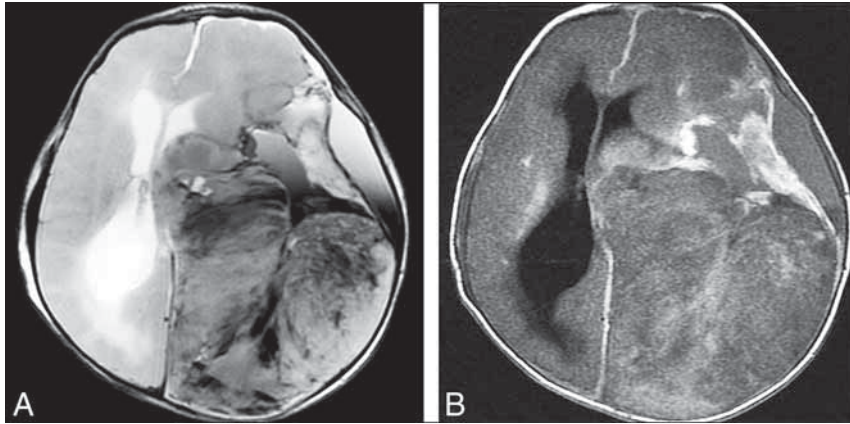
Infant-type hemispheric glioma, NOS. A male neonate child with macrocephaly and bulging fontanelles had a large, heterogeneous-appearing mass on an emergent CT scan (not shown). Axial T2-weighted (A) and postcontrast T1-weighted (B) MR images show a very heterogeneous mass with enhancement involving almost the entirety of the left cerebral hemisphere.
